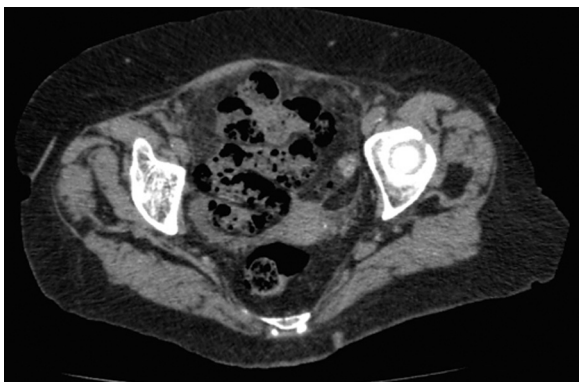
CT of the abdomen and pelvis showing aspect of intestinal pneumatosis.
